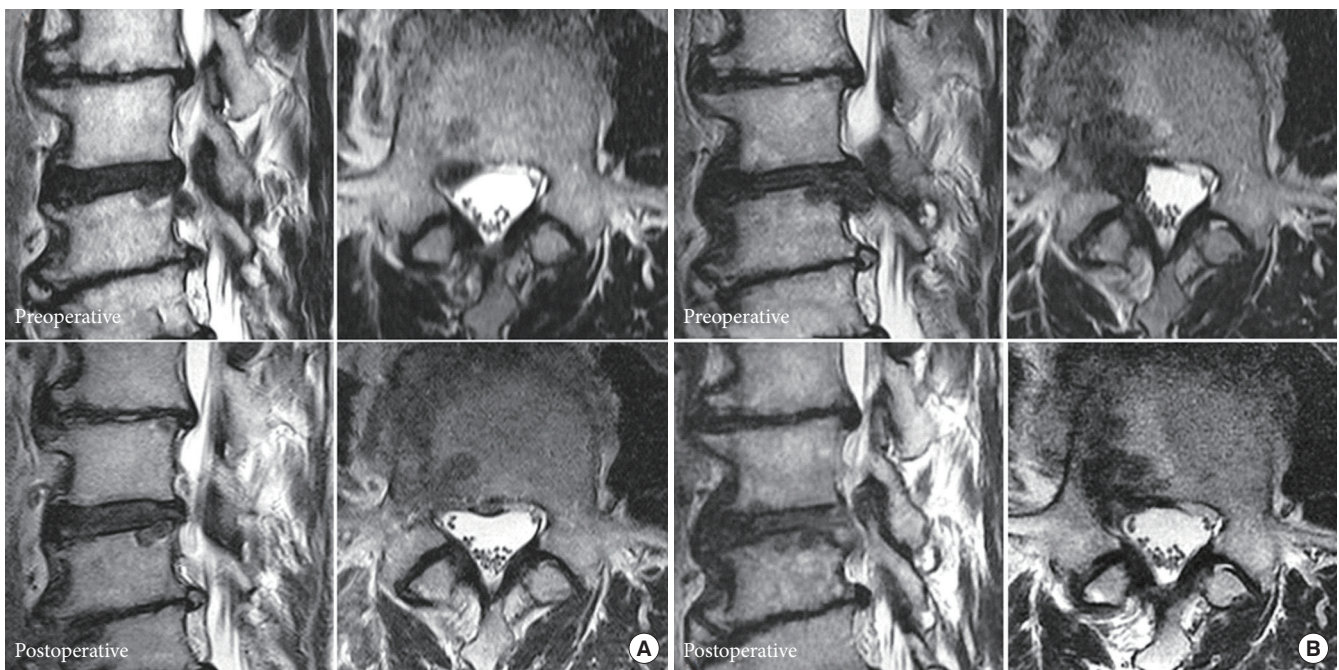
(A) Preoperative magnetic resonance imaging (MRI) of a case with severe lumbar canal stenosis with inferior migration of disc fragment at L3–4 level. (B) Postoperative MRI showing complete removal of inferiorly migrated herniated disc with bilateral decompression without violation of facet joints or muscle damage after percutaneous endoscopic stenosis lumbar decompression.
